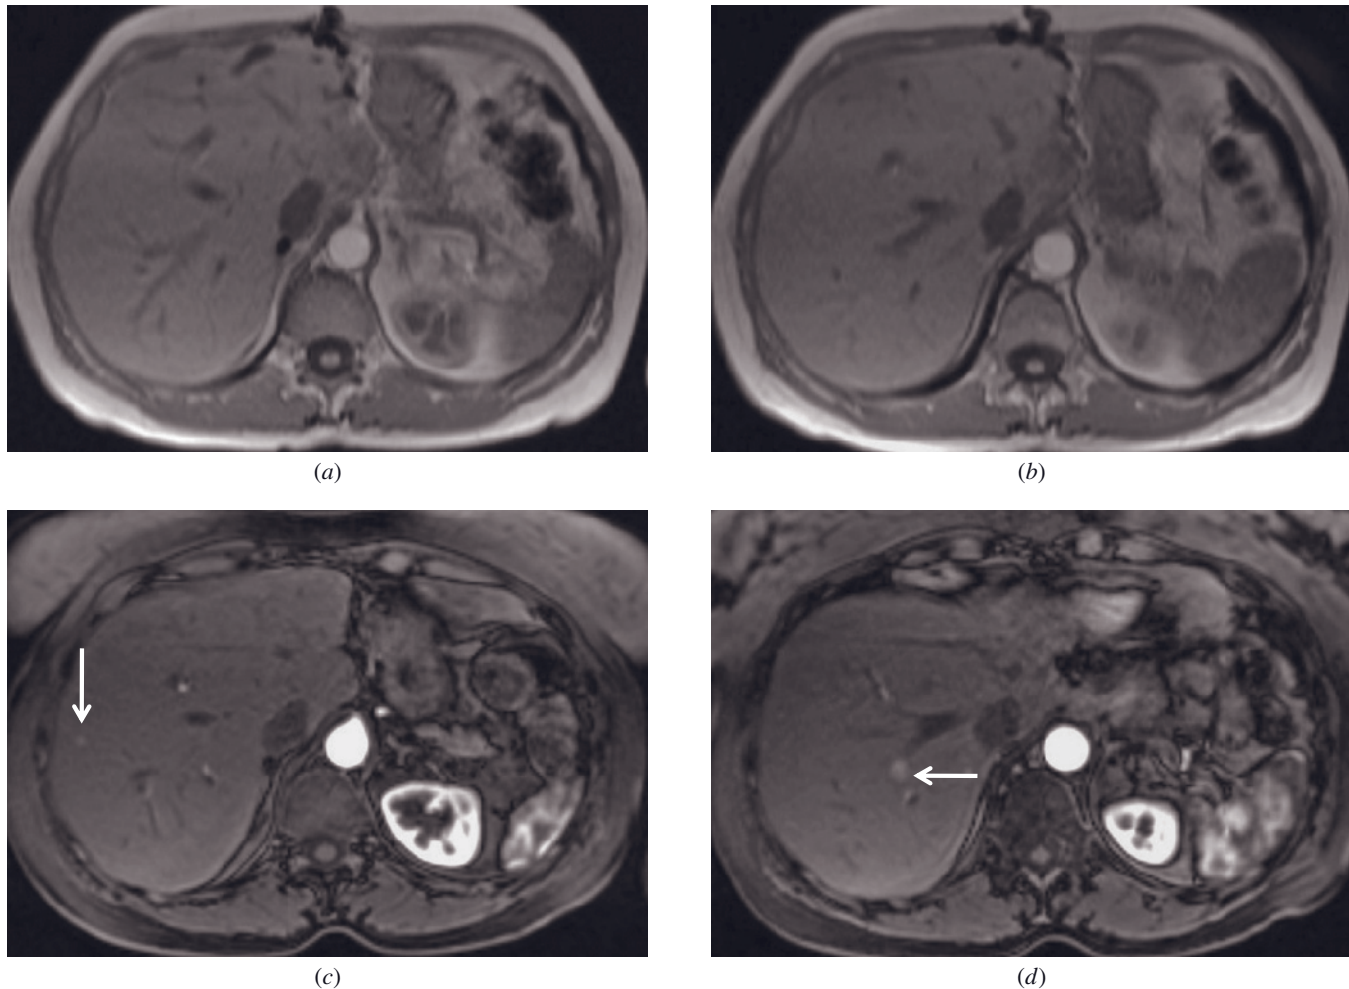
EHAP vs. LHAP. T1-weighted postgadolinium EHAP SGE (*a, b*) and LHAP fat-suppressed 3D-GE (*c, d*) images demonstrate the importance of the timing of early enhancement. While no lesions are detected on EHAP images, two small metastases are detected on LHAP in the same patient.
